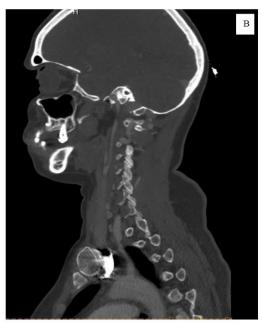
Computed tomography of brachiocephalic arteries and the brain of the patient before surgical intervention (2020): cystogliotic alterations of the left frontal lobe (A); occlusion of the common carotid artery (B).
